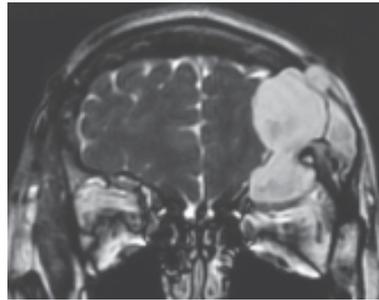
Coronal magnetic resonance imaging shows dumbbell-shaped mucocele extending into the orbit as well as intracranially, compressing left frontal lobe, and extending through the frontal bone into the subcutaneous tissue.
